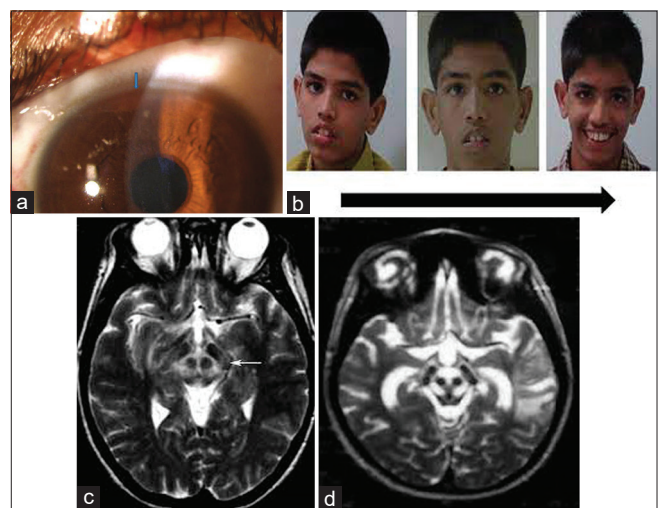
Clinical and brain MRI findings in Wilson's disease. (a) KF ring on slit-lamp examination; (b) Wilsonian dystonic smile. Axial FLAIR MRI brain sequence showing (c) involvement of bilateral thalami and lateral putamen (bright claustrum sign) and (d) the typical "Face of giant panda sign." Axial T2 MRI brain sequence shows pontine hyperintensity
